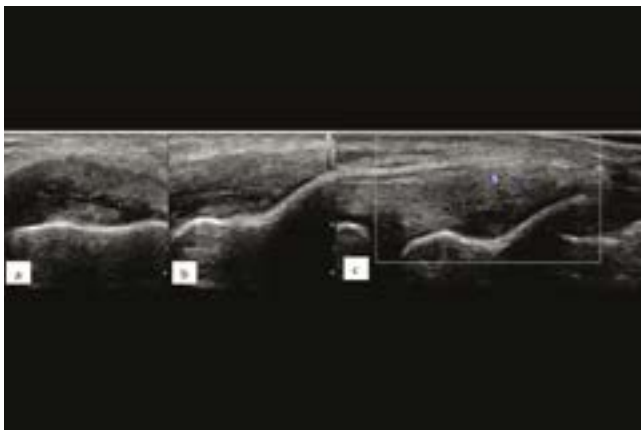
The power doppler signal indicates active inflammation in the tendon, which is indicated by cursors
